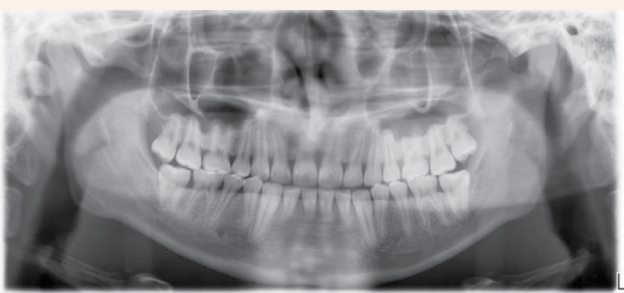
Initial Panoramic X-ray.
